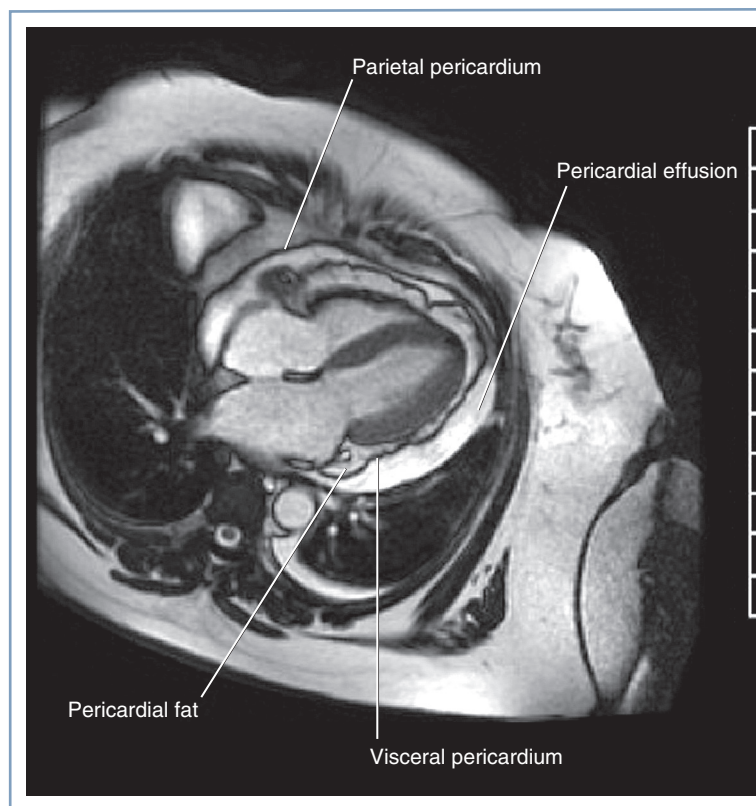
Cardiac magnetic resonance image of pericardial effusion. (Courtesy of Dr. Afshin Farzaneh-Far, University of Illinois at Chicago, Chicago, IL.)
